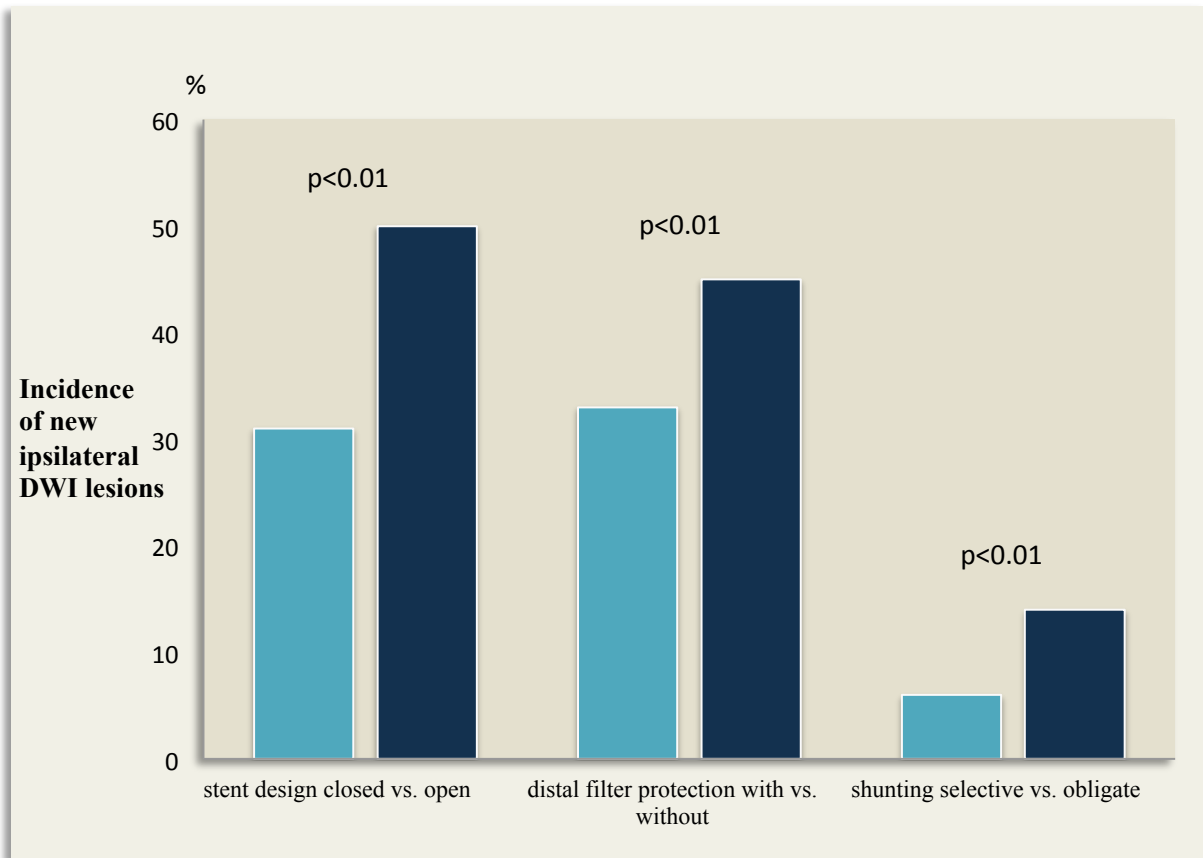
Comparison of 3 procedural variables on the incidence of new ipsilateral DWI lesions. (adapted from Schnaudigel et al¹³⁴)
